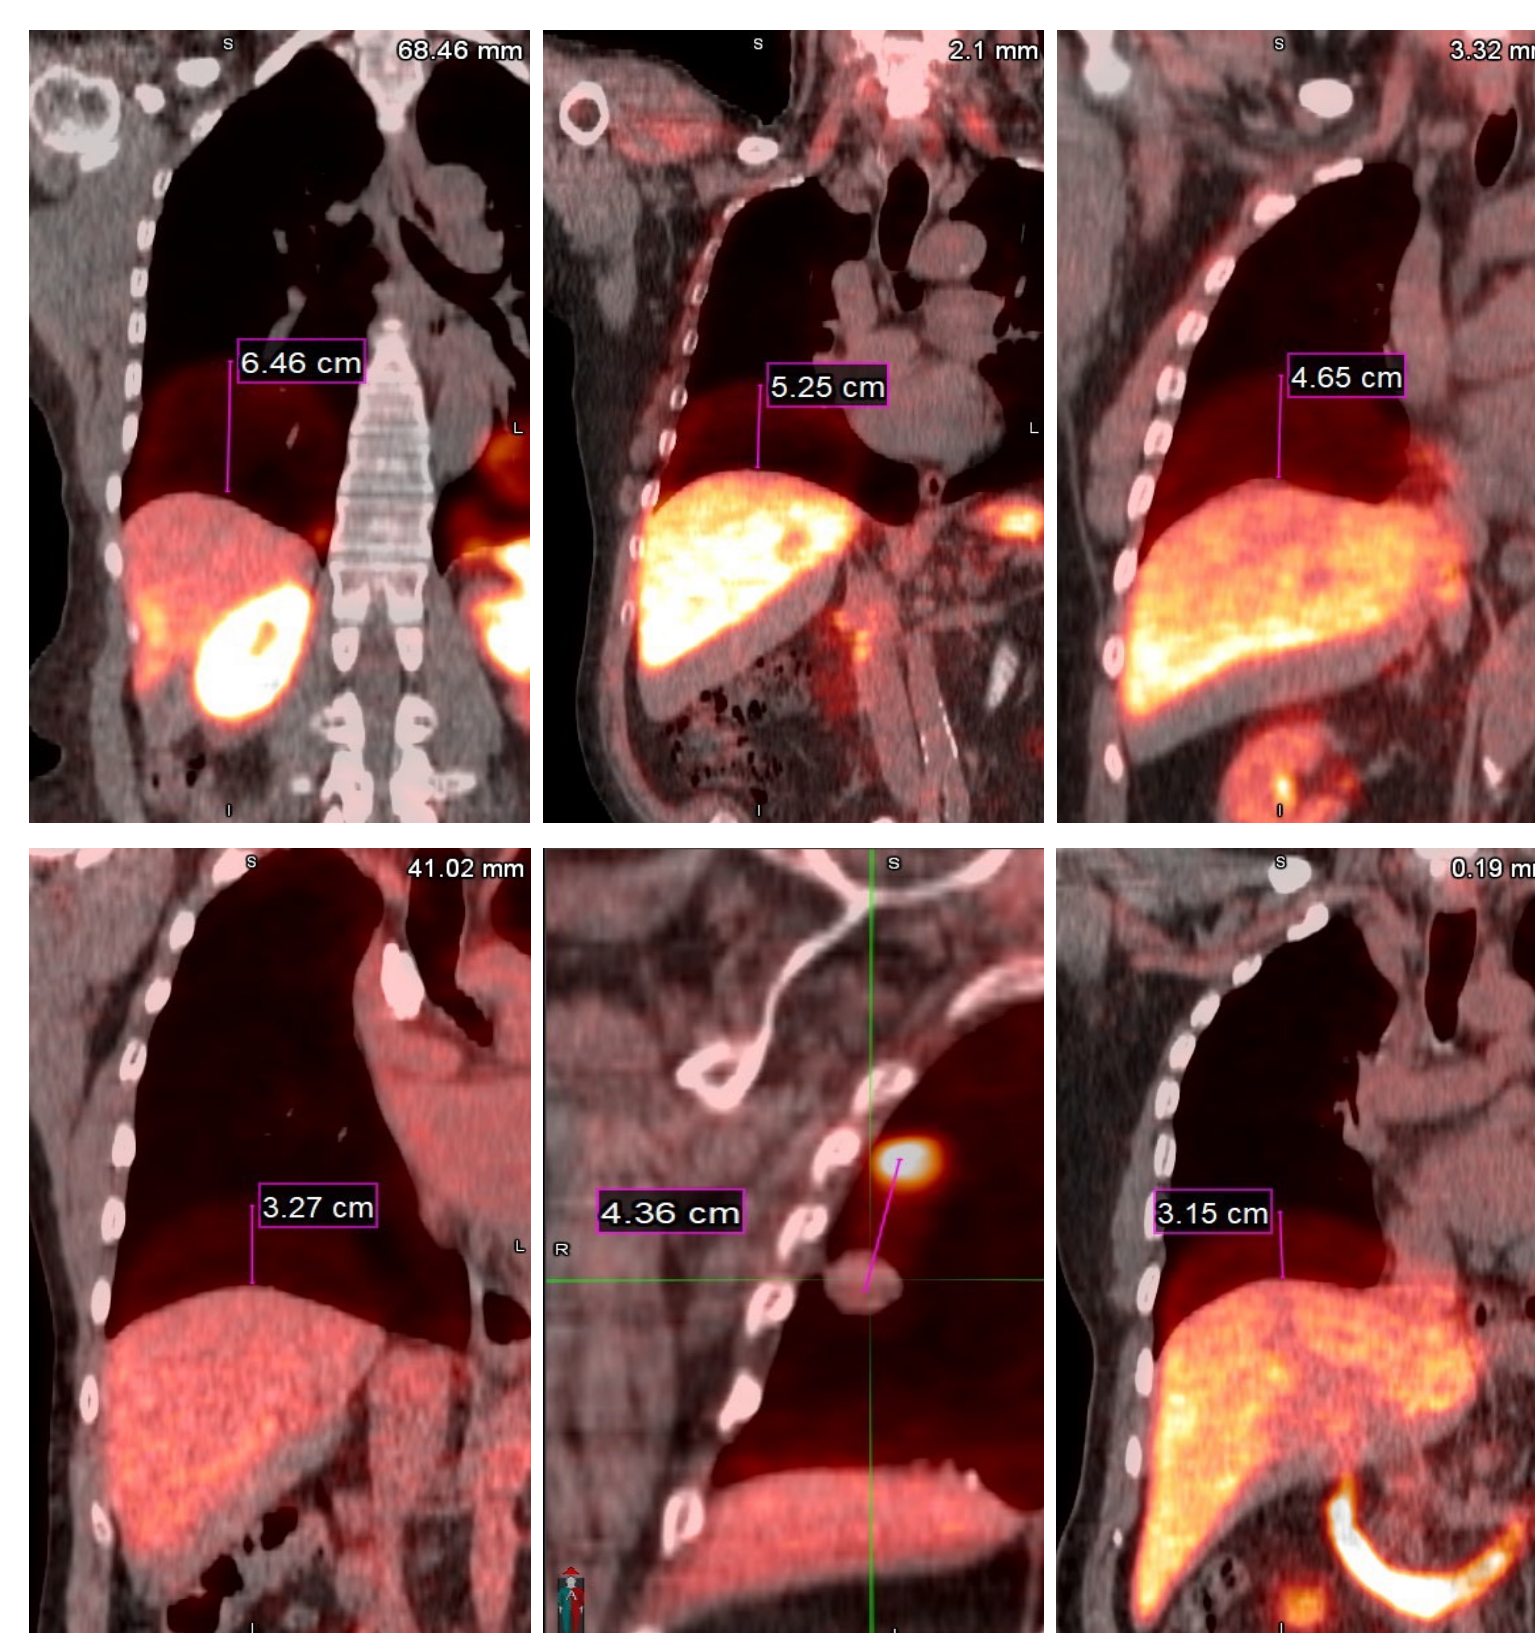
Six examples of PET and CT misregistration using different tracers, visualizing that misregistration is almost always the fault of CT. Tracers are ⁶⁸Ga-Dotatate, ¹⁸F-FCABC, ¹⁸F-FCABC, ¹⁸F-FDG, ¹⁸F-FDG, and ¹⁸F-DCFPyL, respectively.
